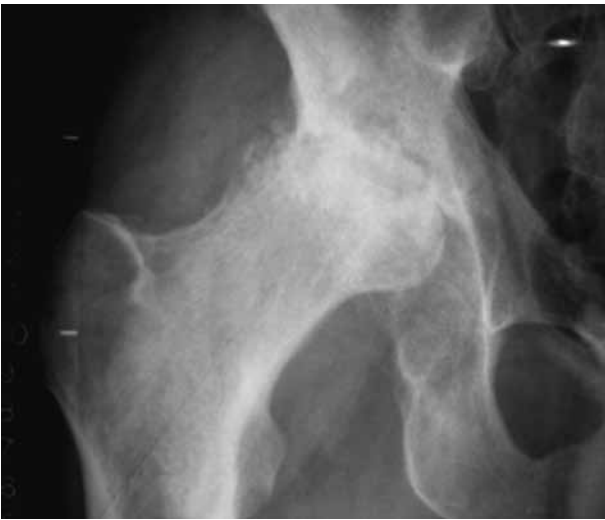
Pre-operative radiograph with end-stage arthritis
